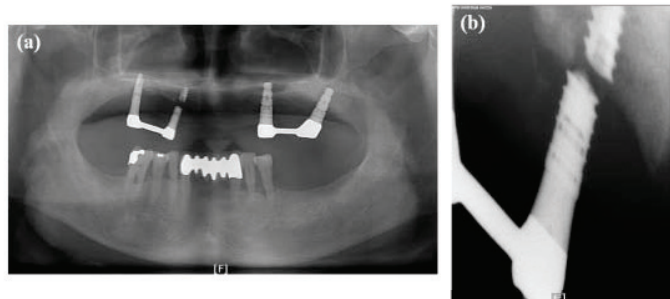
Radiography of sample 4; (a) a panoramic view, (b) a standard view.
